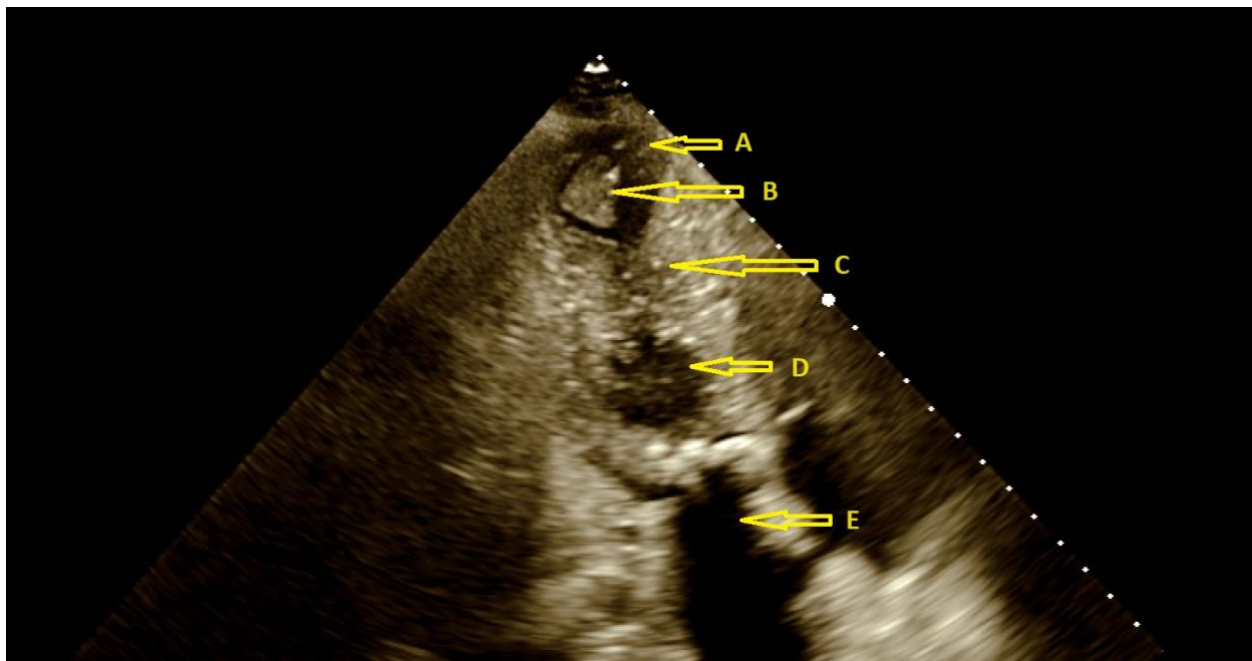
Transthoracic Echocardiogram Without Contrast (A) Left Ventricular Apical Aneurysm. (B) Thrombus. (C) Midcavity Left Ventricular Obstruction. (D) Left Ventricle. (E) Left Atrium.
